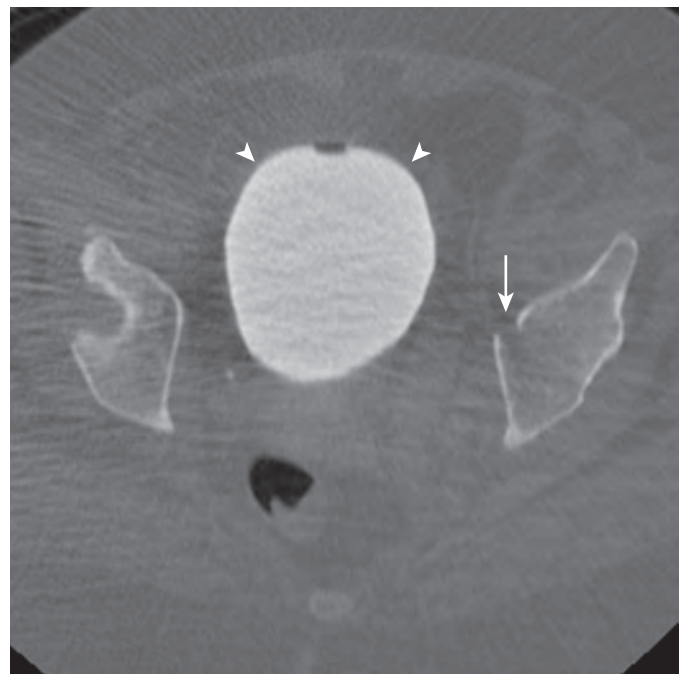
Pelvic trauma with normal findings on CT cystography. A 45-year-old man is evaluated after a motor vehicle collision. CT of the pelvis revealed multiple pelvic fractures and pelvic hemorrhage (left anterior acetabular fracture is denoted by the straight arrow). The patient underwent CT cystography, revealing smooth contour of the urinary bladder wall (arrowheads) and no evidence of bladder injury.
